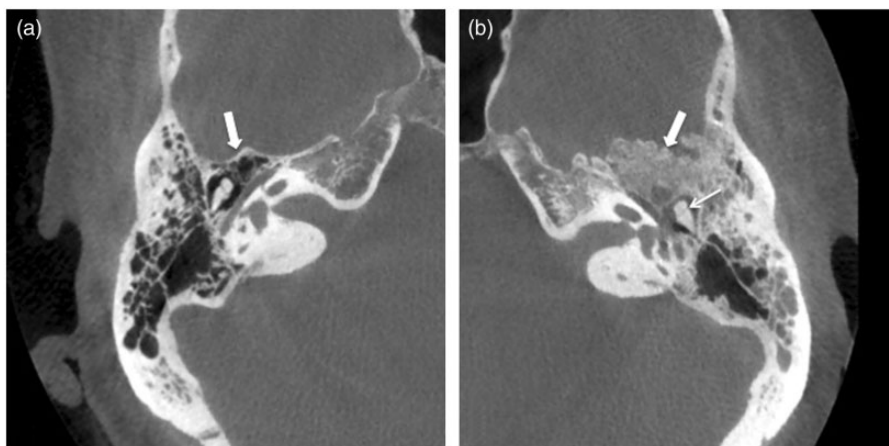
(a) Axial CBCT image of the right temporal bone at the level of the internal auditory canal (same level as (b)). Note the normal aspect of the anterior wall of the middle ear (large arrow) and the clear aerated aspect of the middle ear. (b) Axial CBCT of the left temporal bone at the level of the internal auditory canal. There is clear thickening and hyperostosis of the anterior wall of the middle ear (large arrow). Note the associated soft tissue opacification of the middle ear cavity. There are no signs of ossicular erosion (small arrow).
